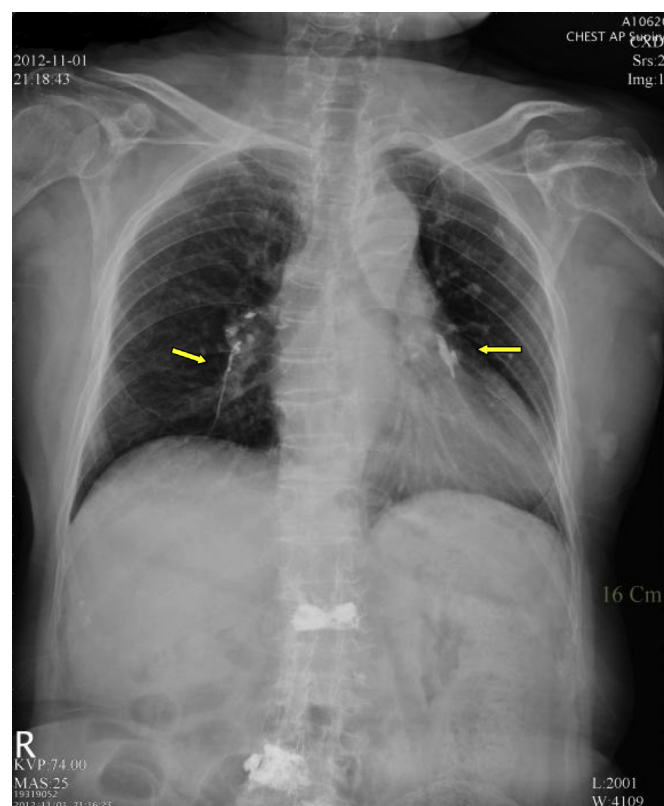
Chest radiograph showing linear-branching opacities in bilateral pulmonary arteries (arrows).
